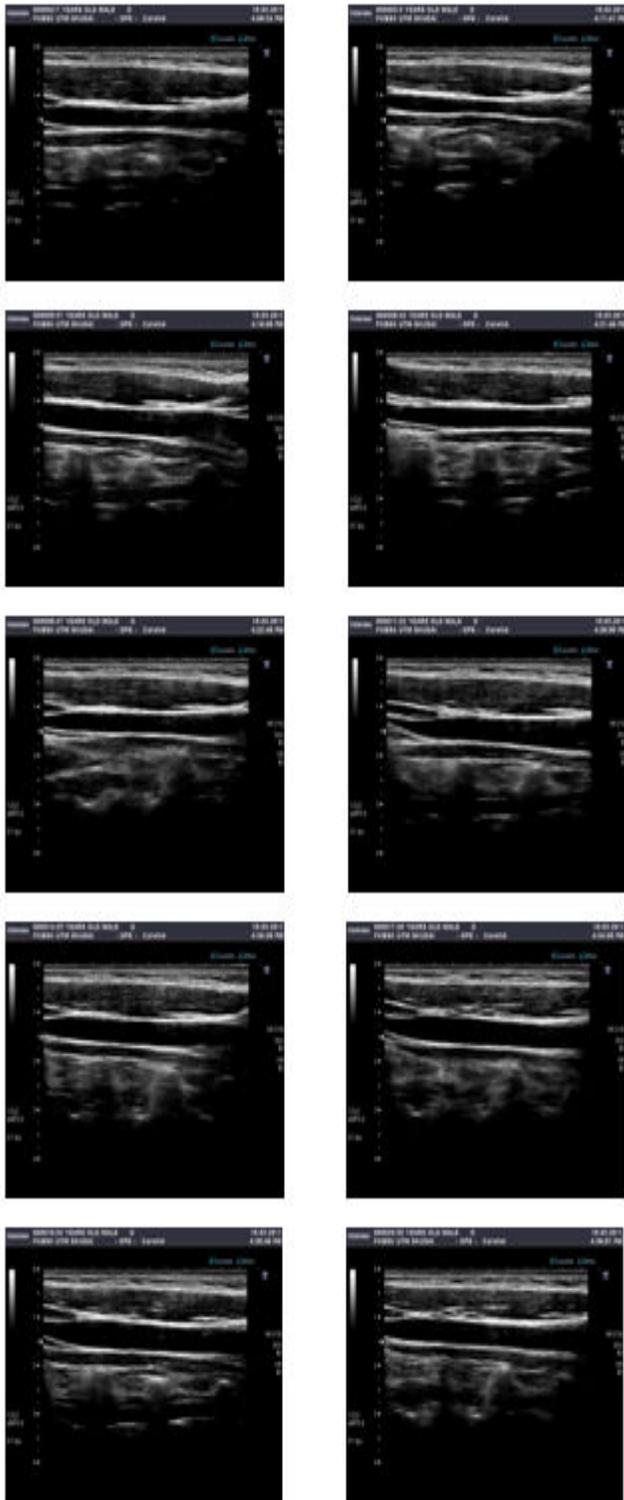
Ten male carotid artery ultrasound images
